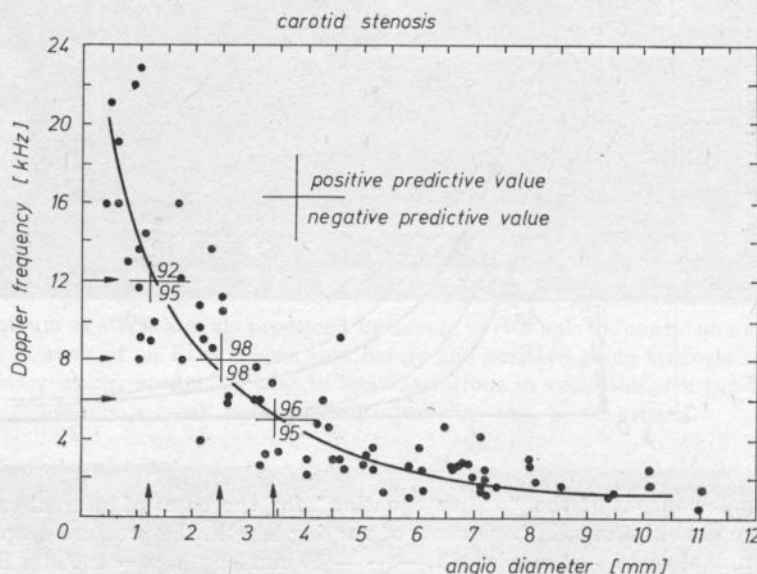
Relationship found by clinical experience between the CWD peak systolic f_{\max} and the angiographically determined diameter of 108 internal carotid arteries. One or both sides were stenotic. The predictive values are for accuracy limits set at ± 0.7 mm and ± 1 kHz (the limits of accuracy for both angiography and Doppler)
